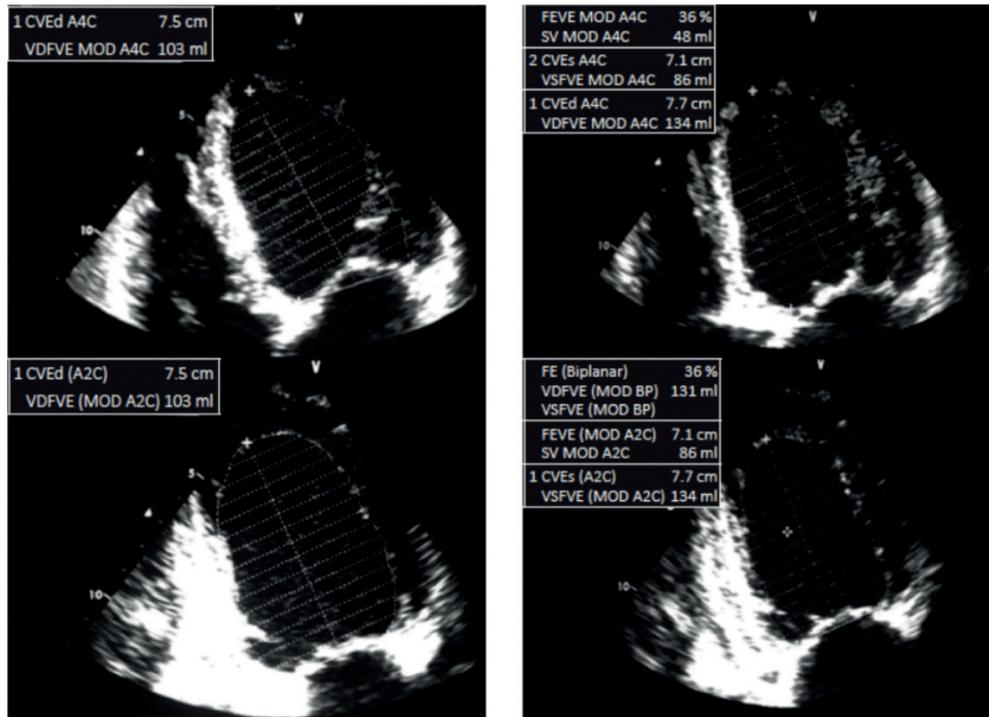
Apical 2- and 4-chamber views for the analysis of ventricular function during systole and diastole. Ejection fraction was calculated using Simpson’s method. CVEd/VDFVE: Left Ventricular End-Diastolic Volume; MOD: Simpson’s Method; FEVE/FE: Left Ventricular Ejection Fraction; CVE/VSFVE: Left Ventricular End-Systolic Volume; SV: Stroke Volume.
